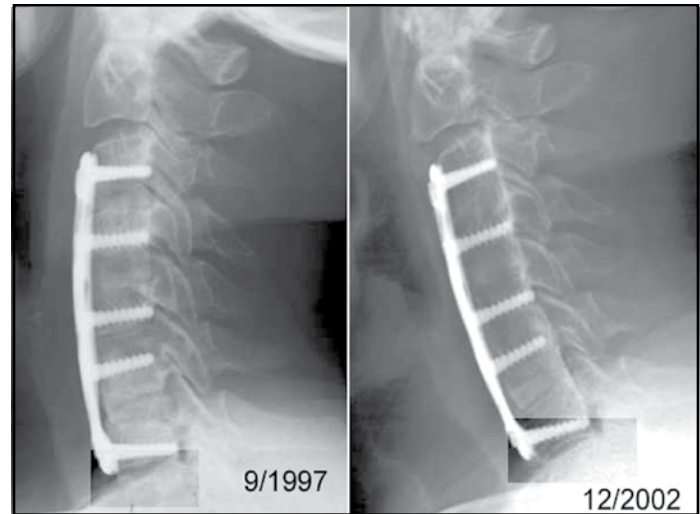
Five-year follow-up radiographs after a four-level fusion for multilevel disc degeneration. Despite the long segment fusion, no adjacent segment disease has developed at C2–3, and the degenerative changes at C6–7, initially present in 1997, have not progressed. The patient is an active individual (marathon runner), and his neck is clinically asymptomatic.
